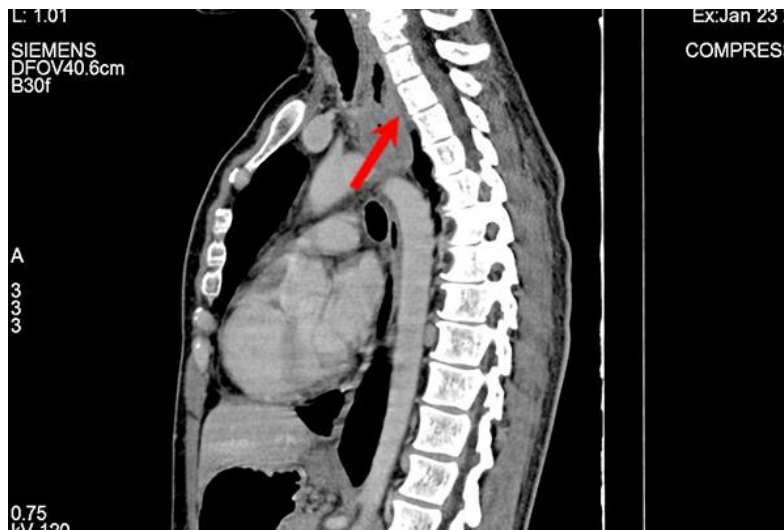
Computed tomography of the chest (lateral section) – Circumferential constriction of the esophageal lumen
